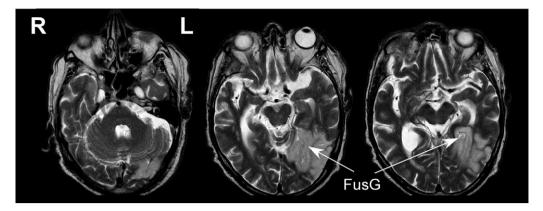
T2-weighted MRI-scan showing ischemic damage to the left occipito-temporal cortex involving the fusiform (FusG), lingual, lateral occipital, and posterior parahip-pocampal gyrus.
